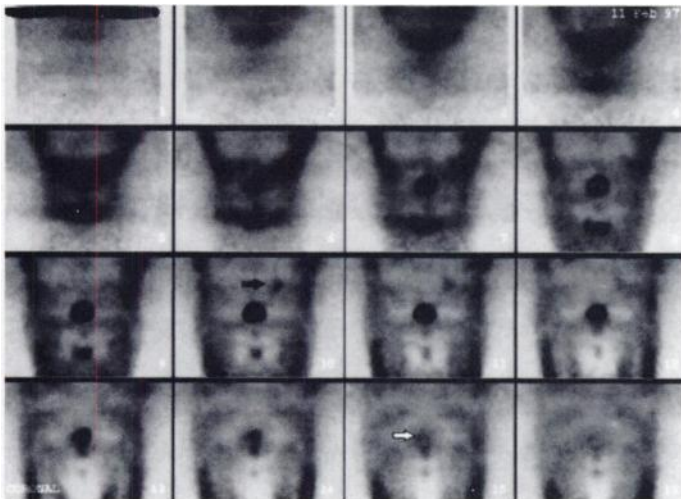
Fluorine-18-FDG coincidence imaging of the abdomen and pelvis demonstrates recurrent tumor in base of bladder (white arrow) and in left pelvic retroperitoneal node (black arrow).
